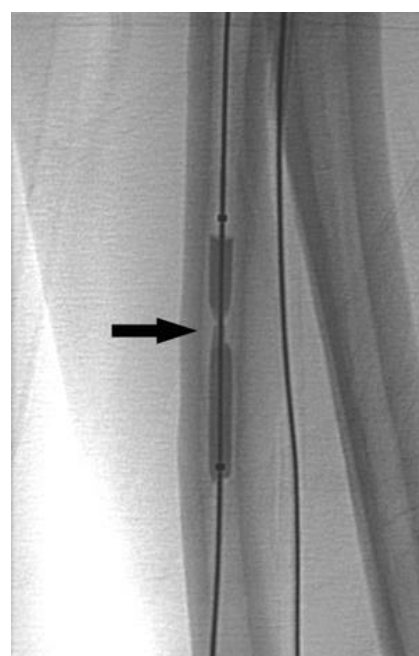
Plain radiograph obtained during balloon inflation shows tight stenosis (arrow) in the distal portion of outflow vein.
